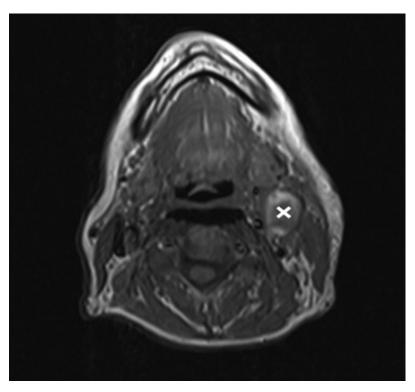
Axial MR view of T1-weighted image demonstrating a 4.1 × 2.4 × 4.9 cm enhancing mass of the left parotid gland consistent with a neoplasm (x).
